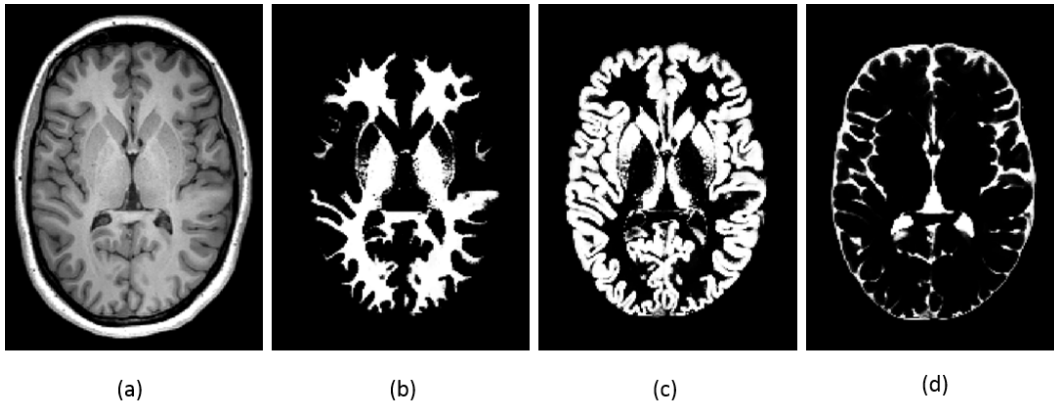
Segmentation of main brain tissues. Figure depicting the segmentation of a (a) T1-weighted brain MRI into (b) WM, (c) GM, and (d) CSF. This exemplary segmentation was done using SPM [61].
